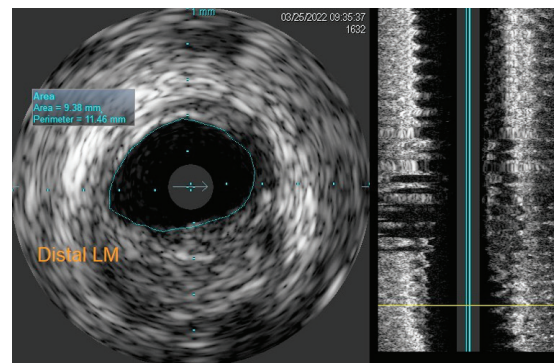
Intravascular ultrasound of distal left main
